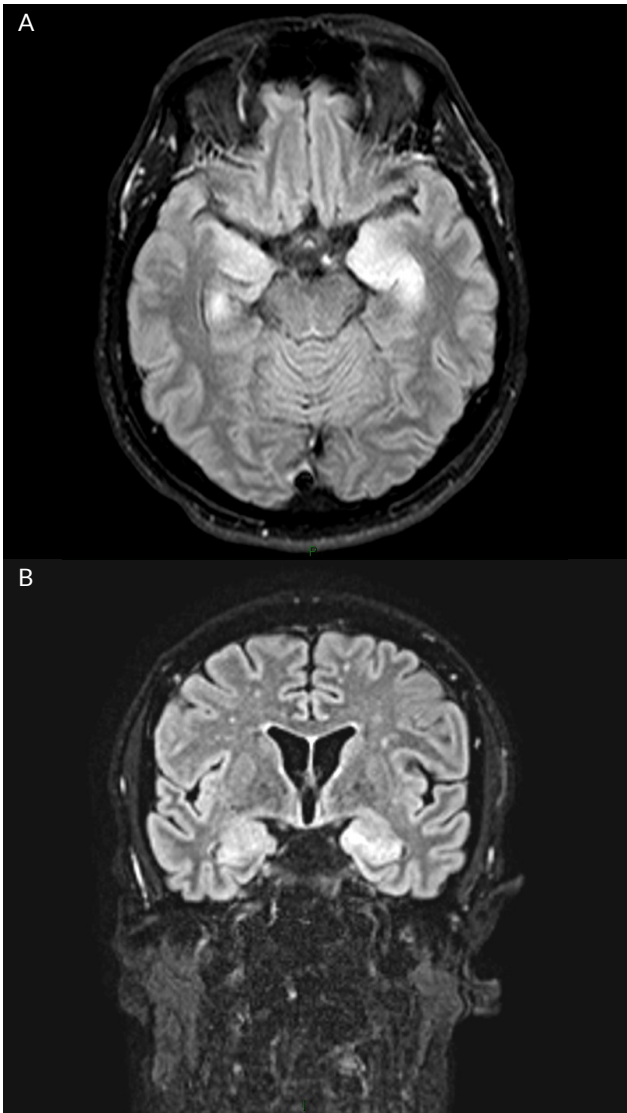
Axial section (A) and coronal section (B) of head MRI imaging showing bilateral intraparenchymal temporal hyperintense lesions on vFLAIR, involving the hippocampi and tonsils.
